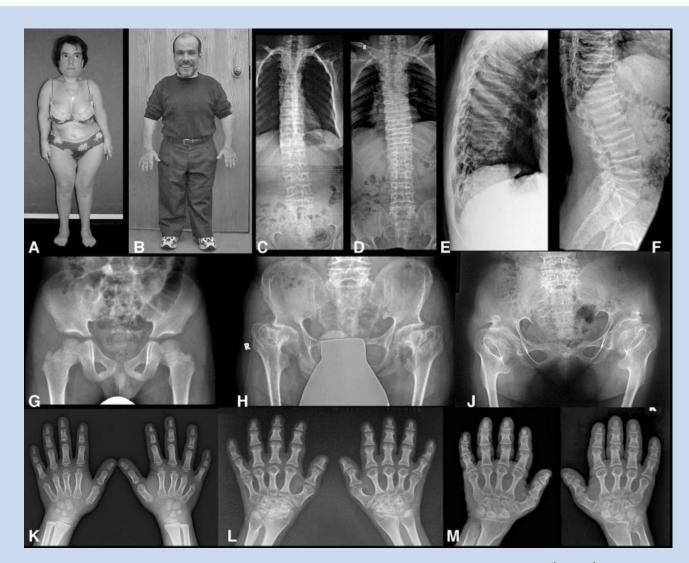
Clinical appearance and radiographic features of SEDM-PM2. Patients 1, 2, and 3 have been reported previously (see text). Shown are patient 6 (panels A, C, E, H, and L), patient 5 (panels B, D, F, J, and M), and patient 4 (panels G and K). The body proportions were those of predominant trunk shortening with less pronounced limb shortening but marked brachydactyly. The radiographs show platyspondyly without anterior tongue formation, marked dysplasia of the proximal femoral metaphyses and epiphyses, as well as flaring of the iliac wings with a marked notch just above the acetabulum (the shape of the ilia being reminiscent of the blade of a halberd), and generalized brachyphalangy.
